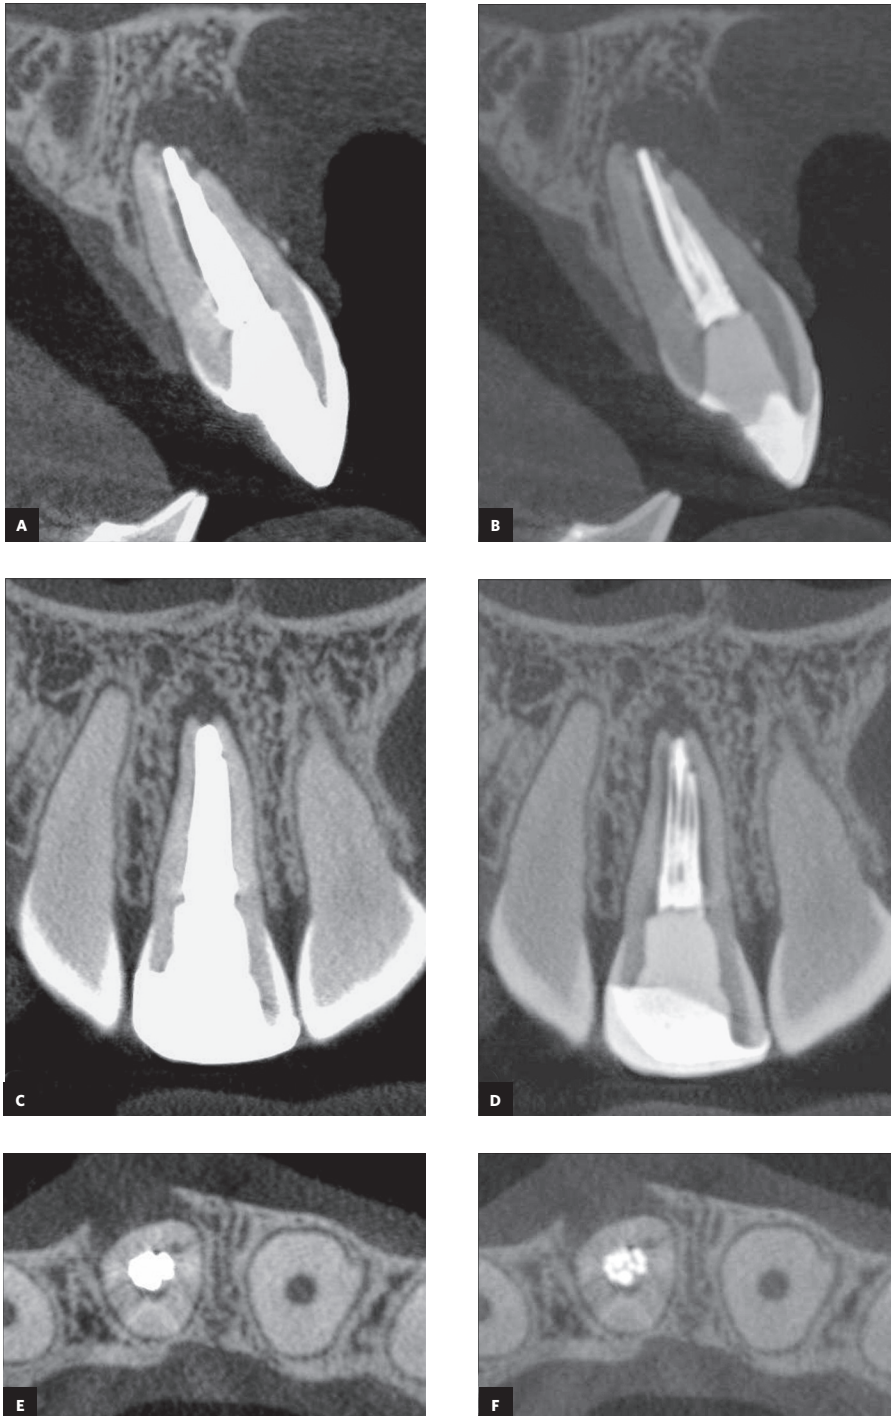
The original CBCT scans (A, C, E) shows white contrast artifact in tooth #11, which make it difficult to verify the failed root canal treatment; (B, D, F) After use the BAR filter a improvement of the image quality was observed. The spaces between the gutta-percha points and the root canal walls were clearly revealed.
